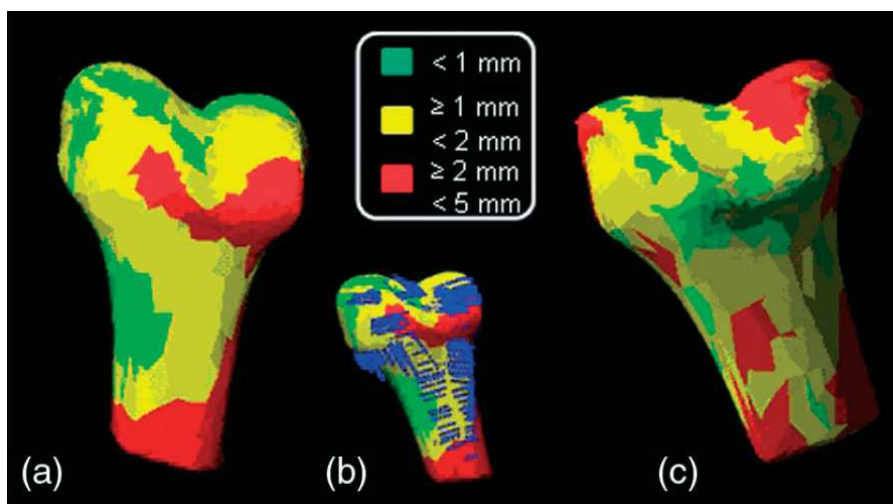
Color maps for the error between the reconstructed 3D models of the cadaveric distal femur (scanned by first (a, b), , and second (c) operator) using ultrasound, and the 3D model reconstructed by bone morphing using a point cloud digitized over the dissected cadaveric femur, by Kilian et. al. [15].
